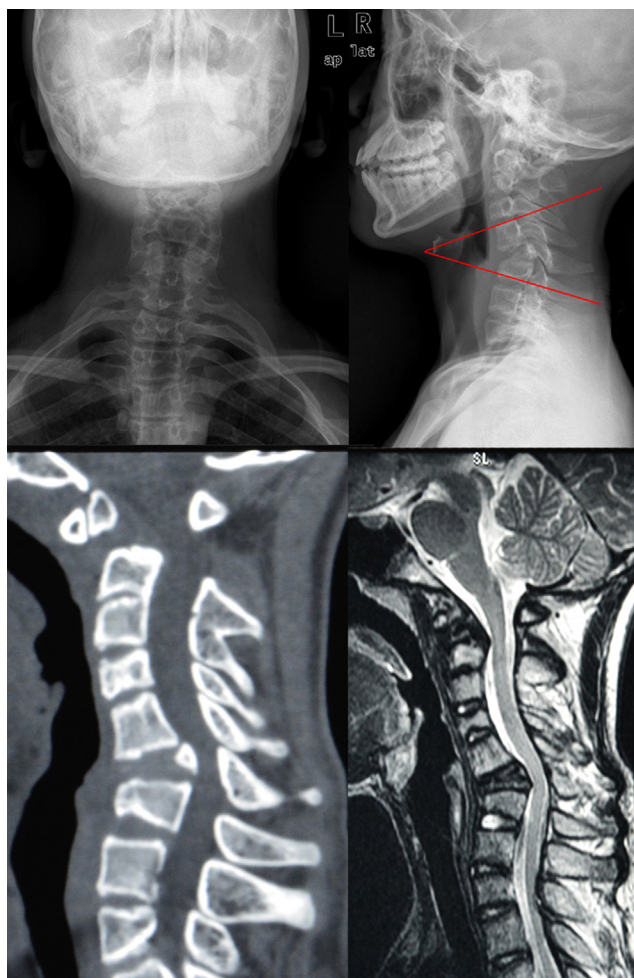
A 14-year-old boy with back neck bulge and no symptoms. X-rays showed a C6 wedging vertebra leading to a cervical angular kyphosis with a degree of 36° resulted in cervical instability. CT presented a separated odontoid process and a complete dislocation of the atlas with respect to the axis associated with Klippel-Feil syndrome, simultaneous with a C6 wedging vertebra. MRI suggested a narrowed spinal canal at the level of atlas-axis and C6.
